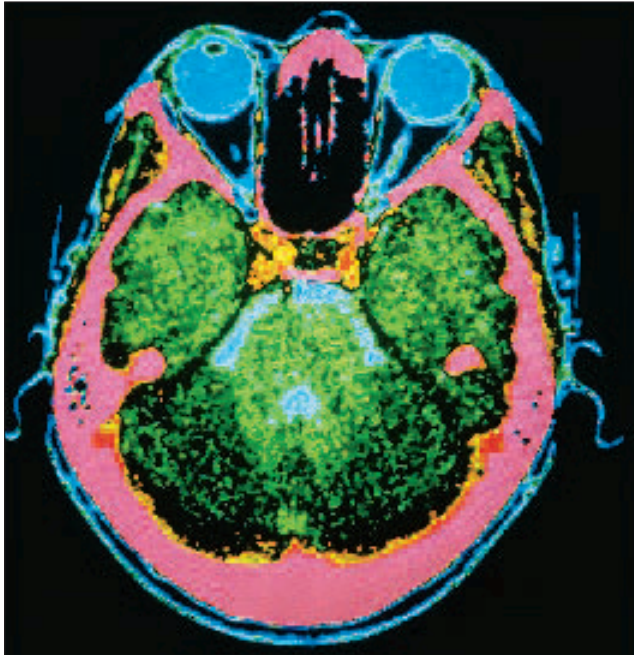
Computed Tomographic (CT) Scan of the Head at the Level of the Eyes. The eyes and skin are shown in blue, bone in red, and the brain in green.
